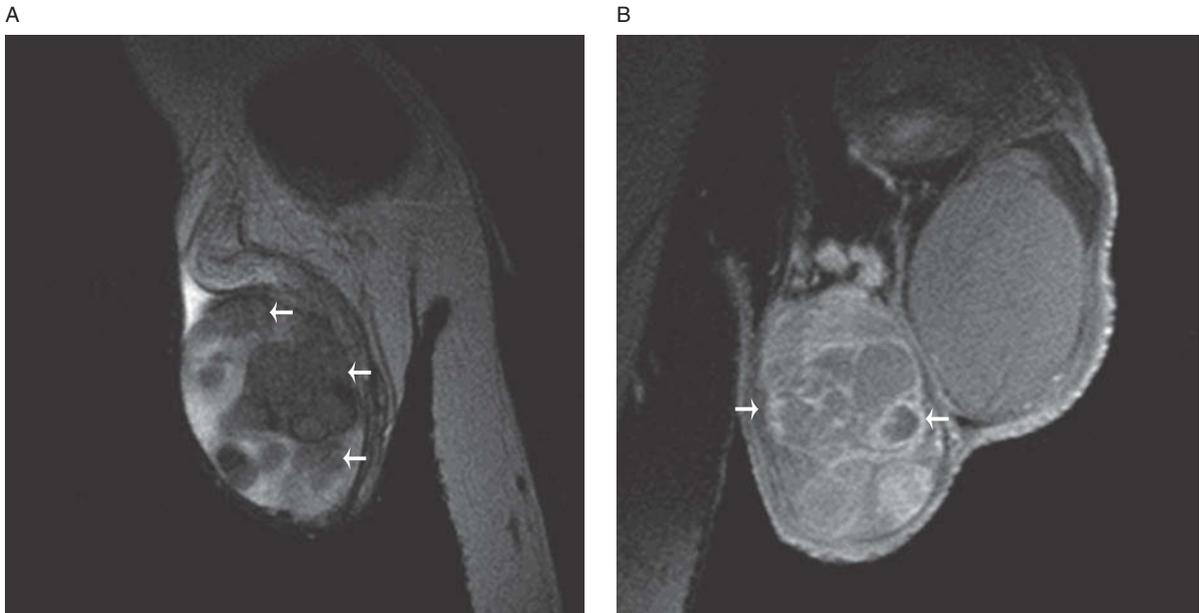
Multifocal right testicular seminoma in a 32-year-old male. Sagittal T2-weighted image (A) reveals multifocal low T2 signal intensity masses (arrows) in the right testicle. Coronal contrast-enhanced T1-weighted image with fat saturation (B) demonstrates heterogeneous enhancement of the dominant right testicular mass with thick internal septations (arrows).
